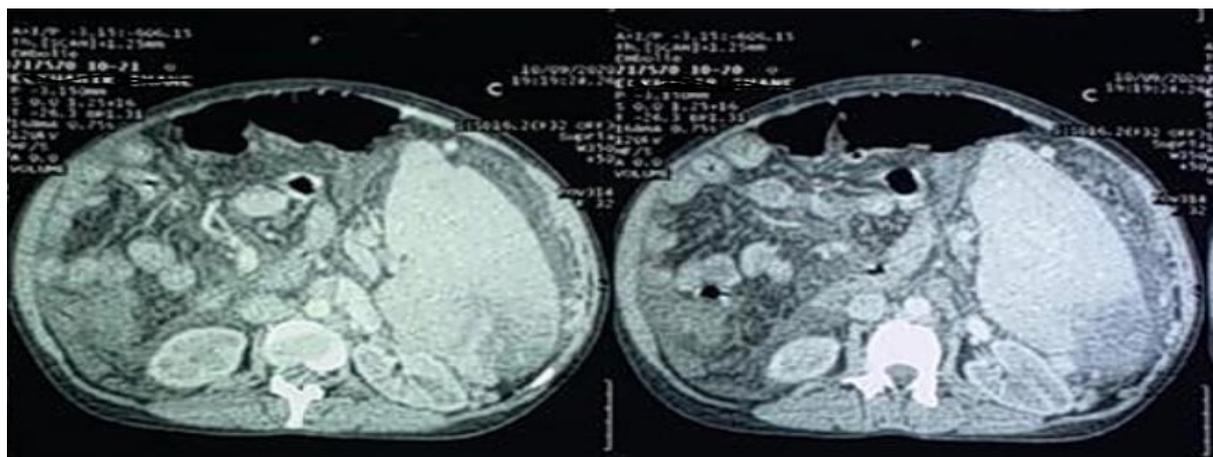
Abdominal CT scan showing an enlarged spleen with a site of a center infarction and extra vasation of the contrast product in the arterial phase suggesting active bleeding
